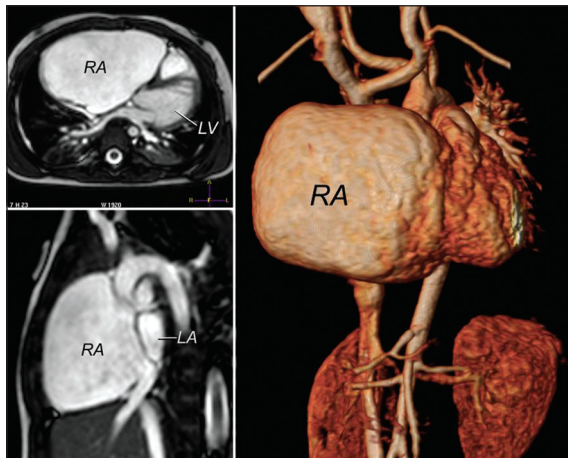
Cardiac MRI bright blood axial (upper left), bright blood parasagittal (lower left), and 3-D reconstruction (right) in case 1 showing the RA enlargement in comparison with the LA and LV. MRI: Magnetic resonance imaging, 3-D: Three-dimensional, RA: right atrium, LA: Left atrium, LV: Left ventricle
